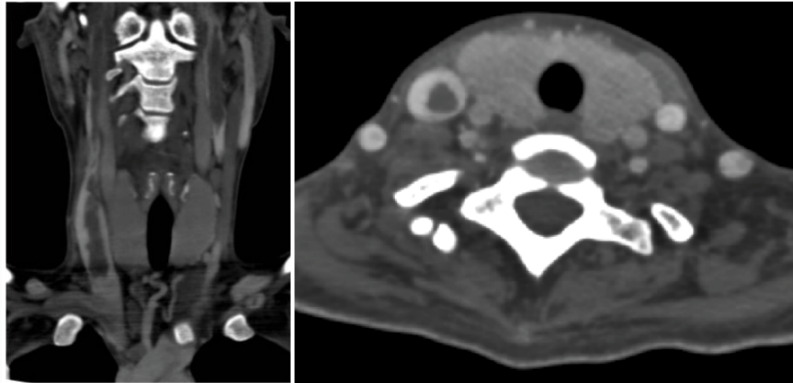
Neck CTA showed right jugular vein thickening and bilateral jugular vein thrombosis.
